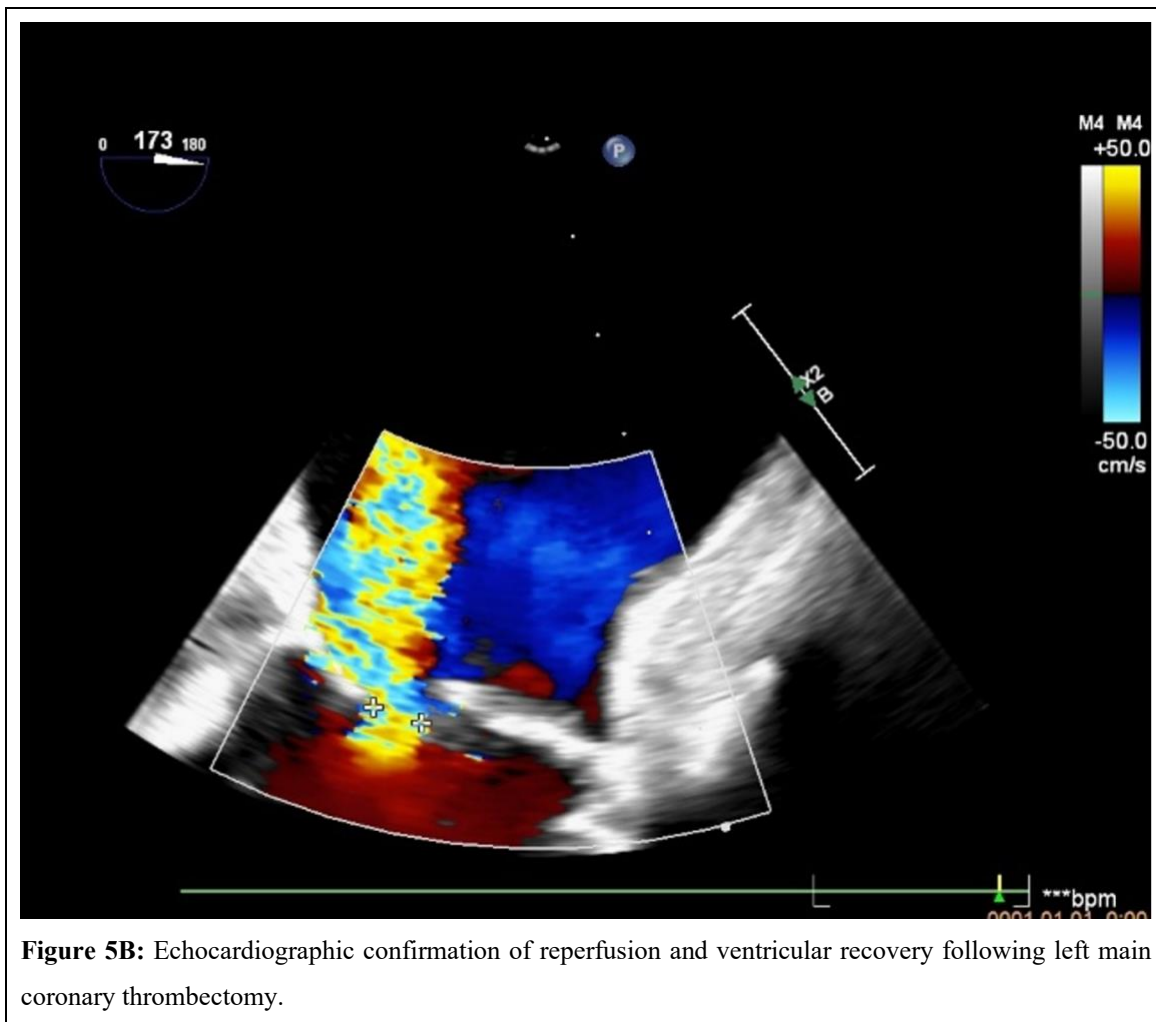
Echocardiographic confirmation of reperfusion and ventricular recovery following left main coronary thrombectomy.
